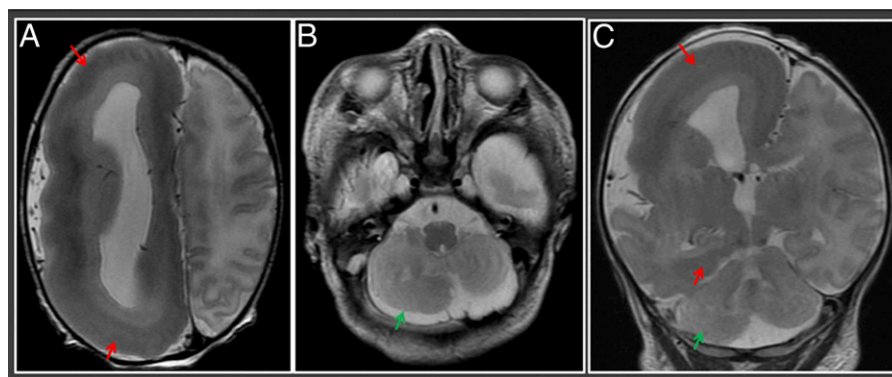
Axial (A) and coronal (C) T2-weighted magnetic resonance images demonstrate overgrowth of the right cerebral hemisphere with an enlarged, misshapen right lateral ventricle. There is absent sulcation in the right frontal and parietal lobes and reduced sulcation in the right temporal lobe. The cortex is markedly thickened (red arrows) in the right frontal and parietal lobes, as well as in the right medial temporal lobe. Axial T2 weighted image (B) demonstrates asymmetrically enlarged right cerebellar hemisphere (green arrow), also visualized in (C).
